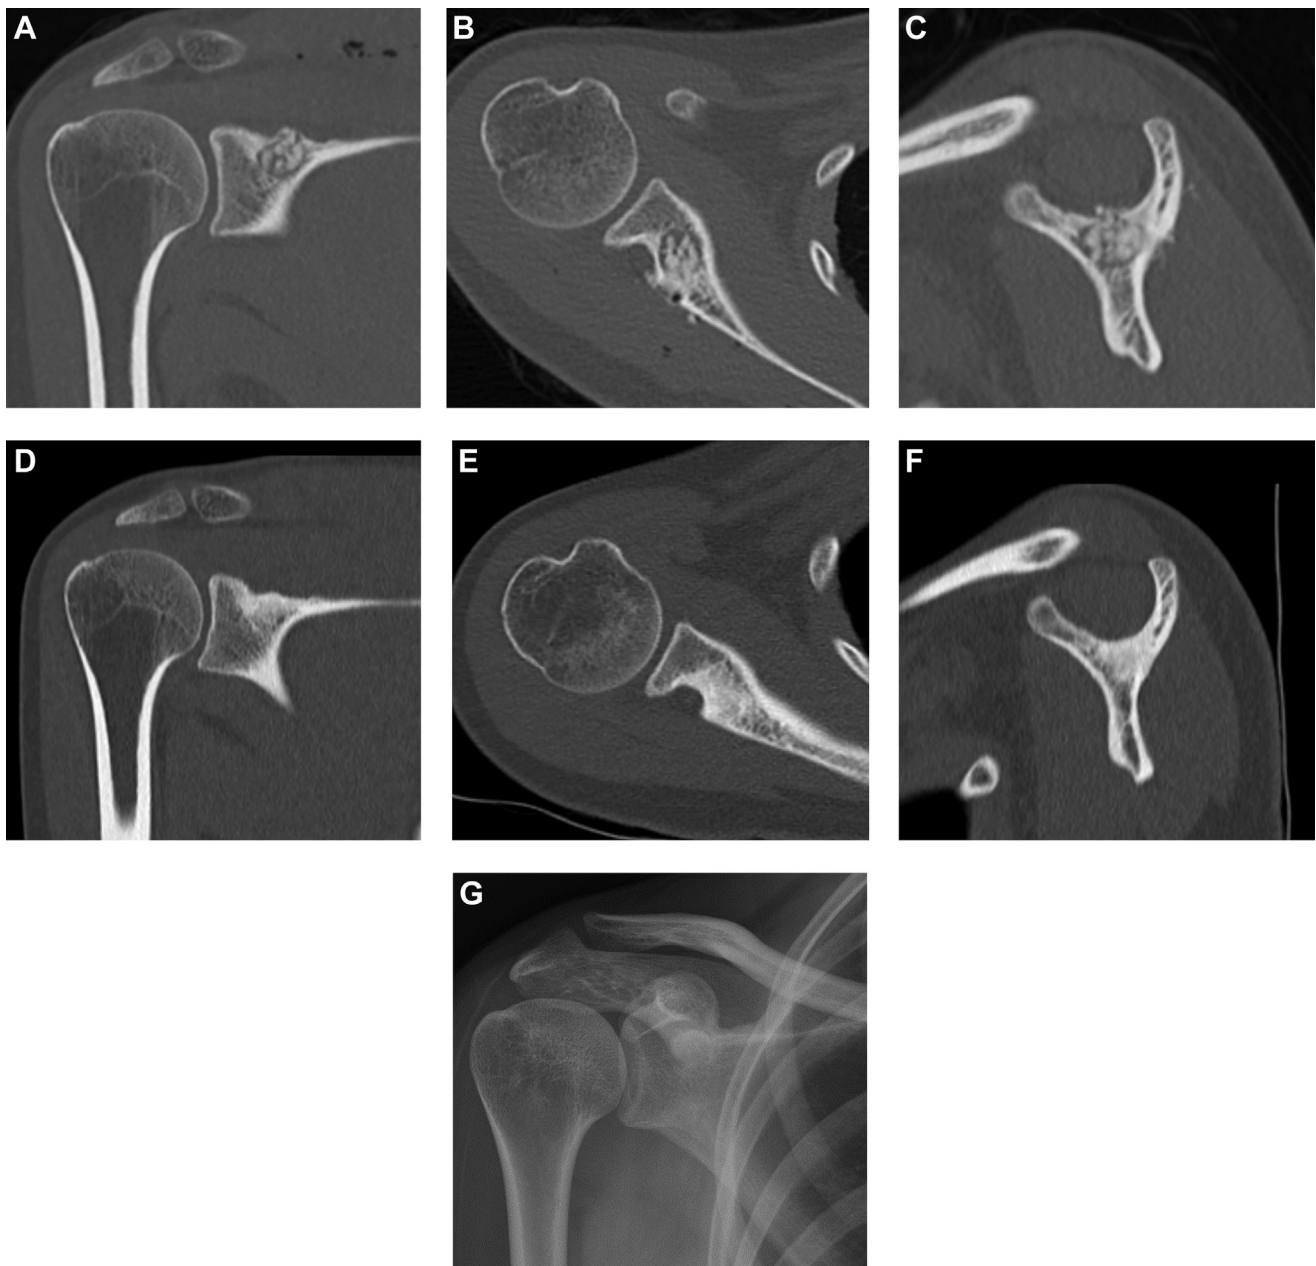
(A) CT coronal view just after operation. (B) CT sagittal view just after operation. (C) CT axial view just after operation. (D) CT coronal view 1 year postoperatively. (E) CT sagittal view 1 year postoperatively. (F) CT axial view 1 year postoperatively. (G) Frontal radiography, 1 year postoperatively. There has been no tumor recurrence, and the tumor is filled with new bone. CT, computed tomography.
